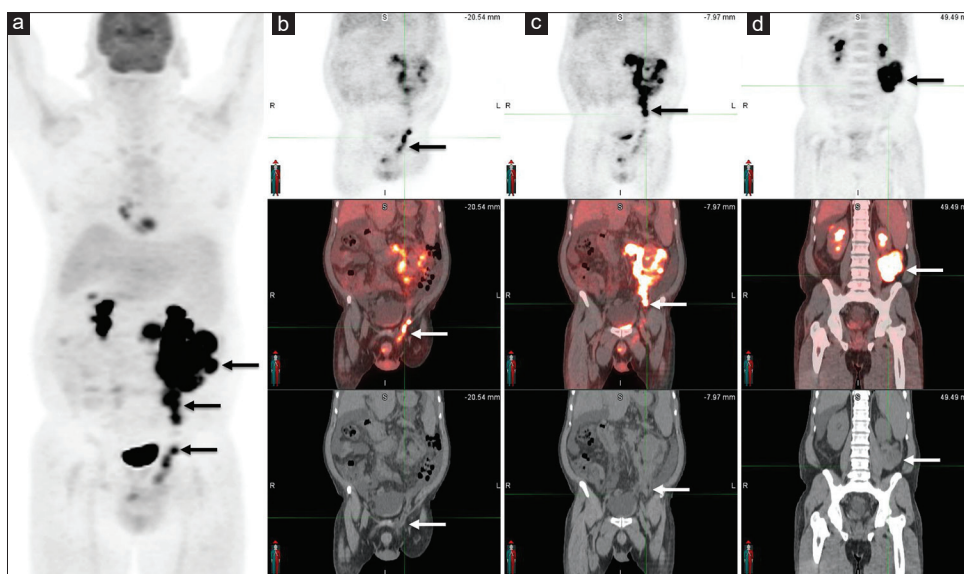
Multiple images from FDG PET/CT study. The whole-body MIP image (a) shows multiple foci of intense uptake seen extending from the left groin to the left kidney (black arrows). Panels (b-d) are coronal PET, fused coronal PET/CT and coronal CT images at multiple levels (from anterior to posterior respectively) showing hypermetabolic tumor foci extending along the left inguinal canal, to the retroperitoneal space, and the left perinephric space
